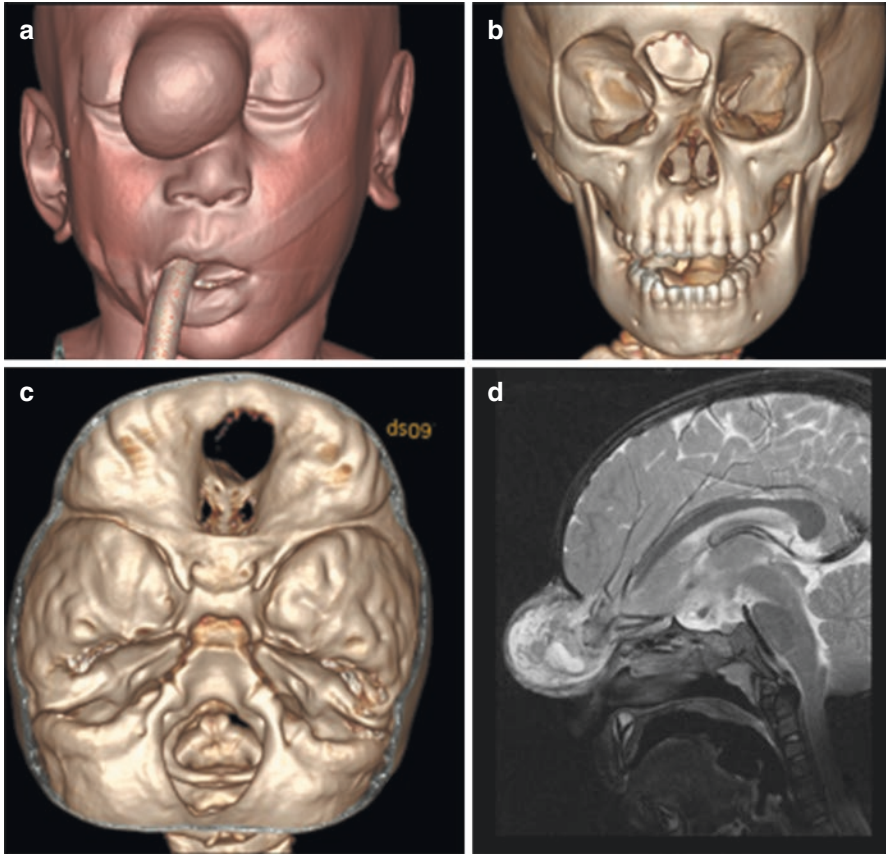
(a) Soft tissue reconstruction on 3D CT of a child with sincipital encephalocele. (b) 3D CT reconstruction of the skull demonstrating the frontal defect and its associated medial telecanthus. (c) intracranial reconstruction of the same scan showing the internal defect centred between the frontal and ethmoidal bones. (d) Magnetic resonance imaging (MRI) sagittal section showing the frontoethmoidal meningoencephalocele with the anterior cerebral arteries in the contents of the sac
